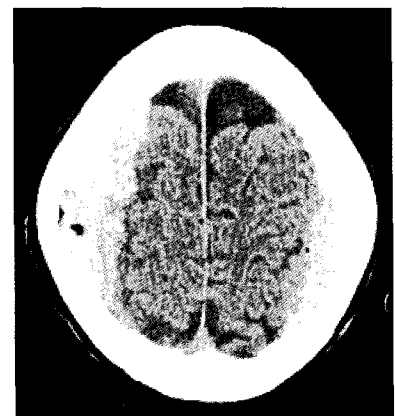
Postoperative computed tomography scan demonstrates a newly developed high density area over bilateral hemisphere.
